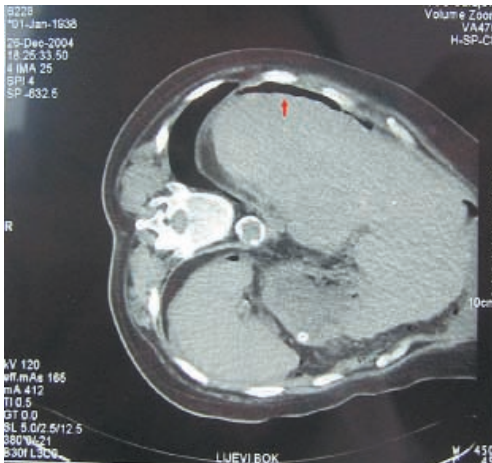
Movement of air collection ventrally on CT scan at lateral decubitus position.
